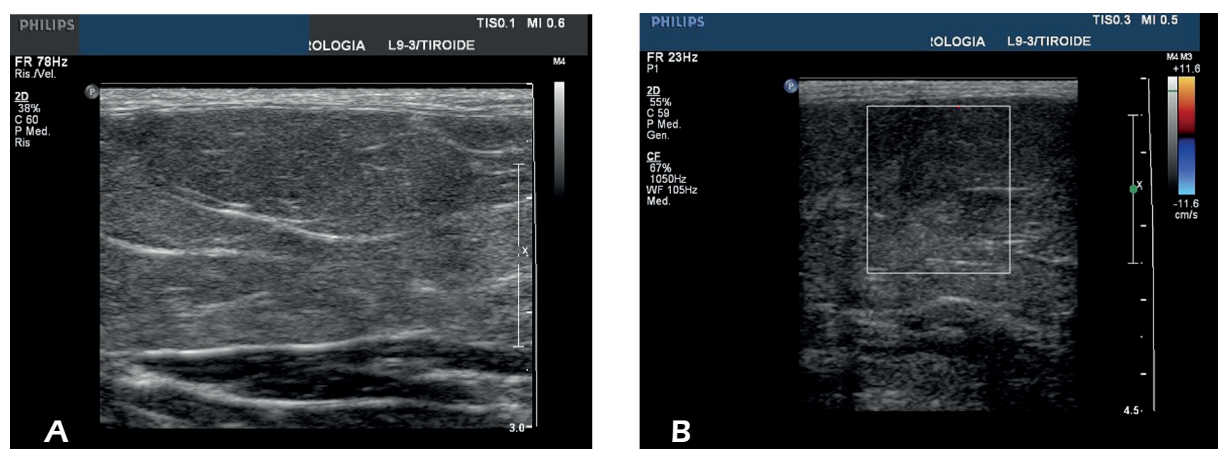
A, B, These figures show echogenic encapsulated masses located in the subcutaneous tissue, with no acoustic shadowing and no color Doppler flow.
